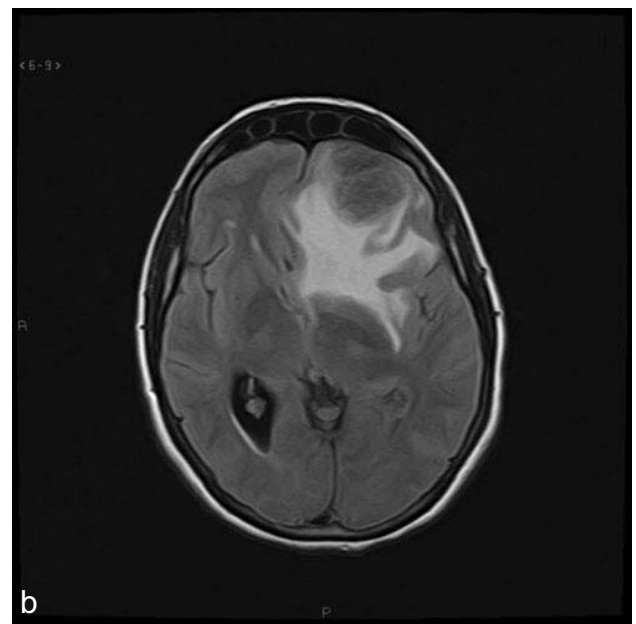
T2 axial and FLAIR show surrounding vasogenic edema in left frontal region.
